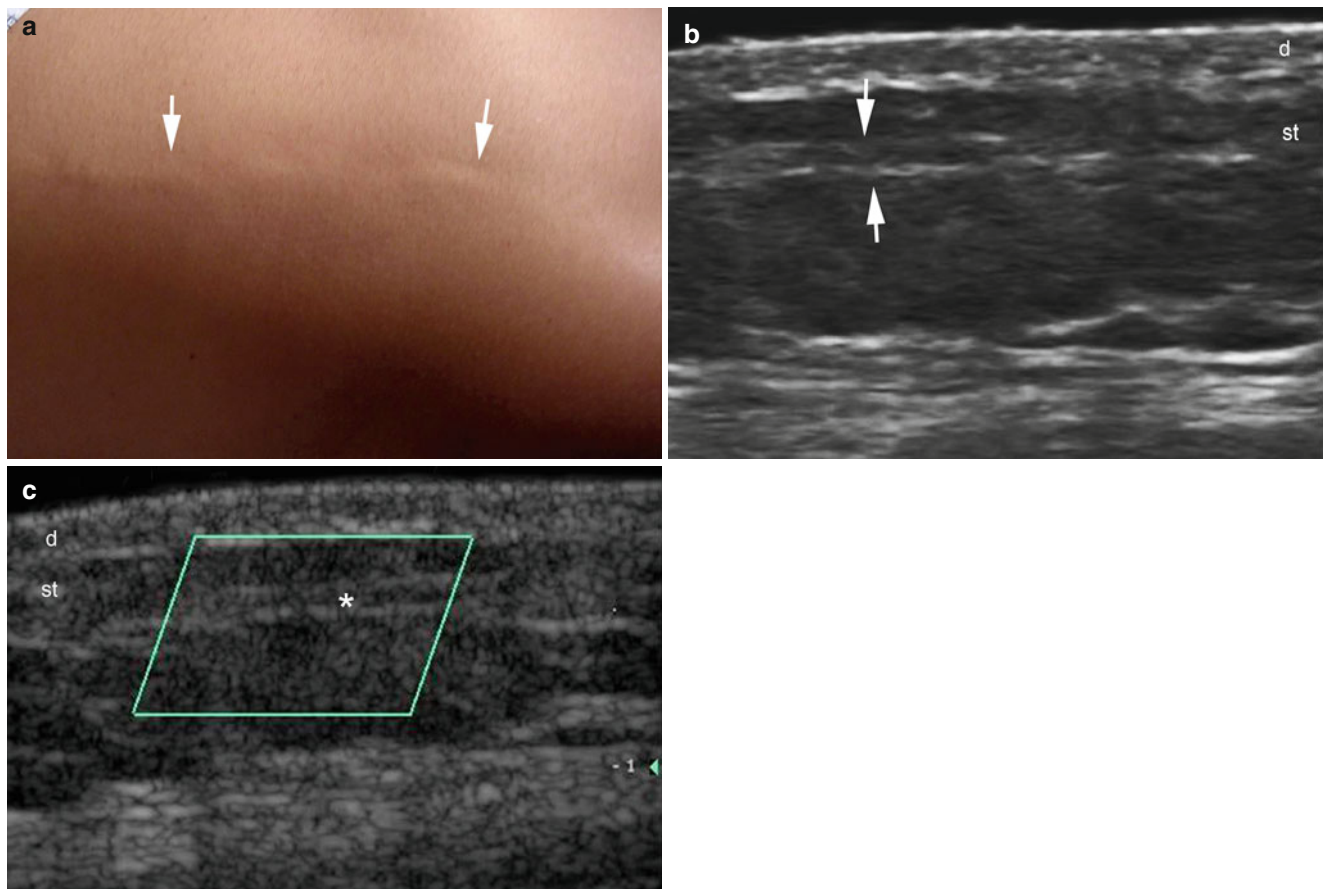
(a–c) Mondor’s disease. (a) Clinical image demonstrates a cord-like band (*arrows*) in the right aspect of the abdominal wall. (b) Grey scale ultrasound image (longitudinal view) shows a dilated subcutaneous vessel (*arrows*) with hypoechoic thrombotic material
